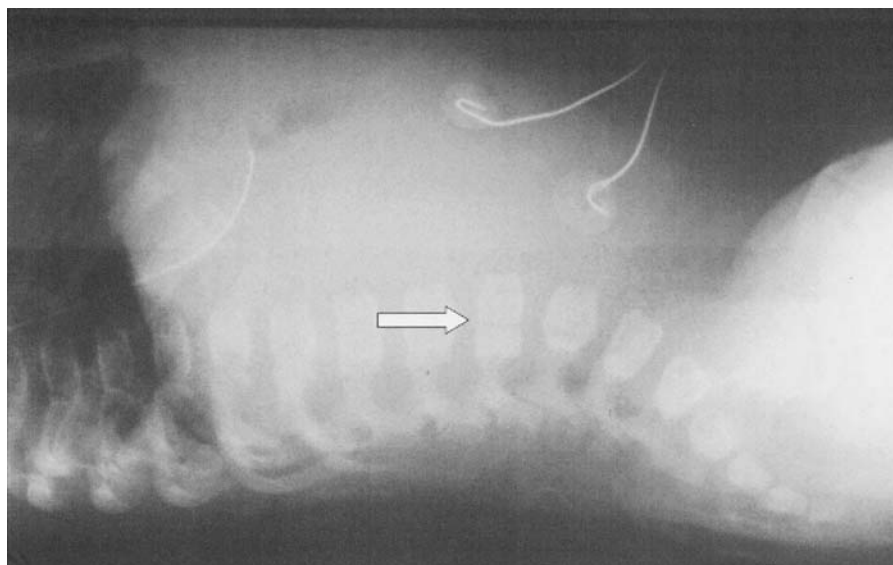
Antemortem lateral view X-ray of the lumbar spine revealing a vertically oriented lucency through the vertebral body of L3 that was thought to represent a fracture (arrow).
